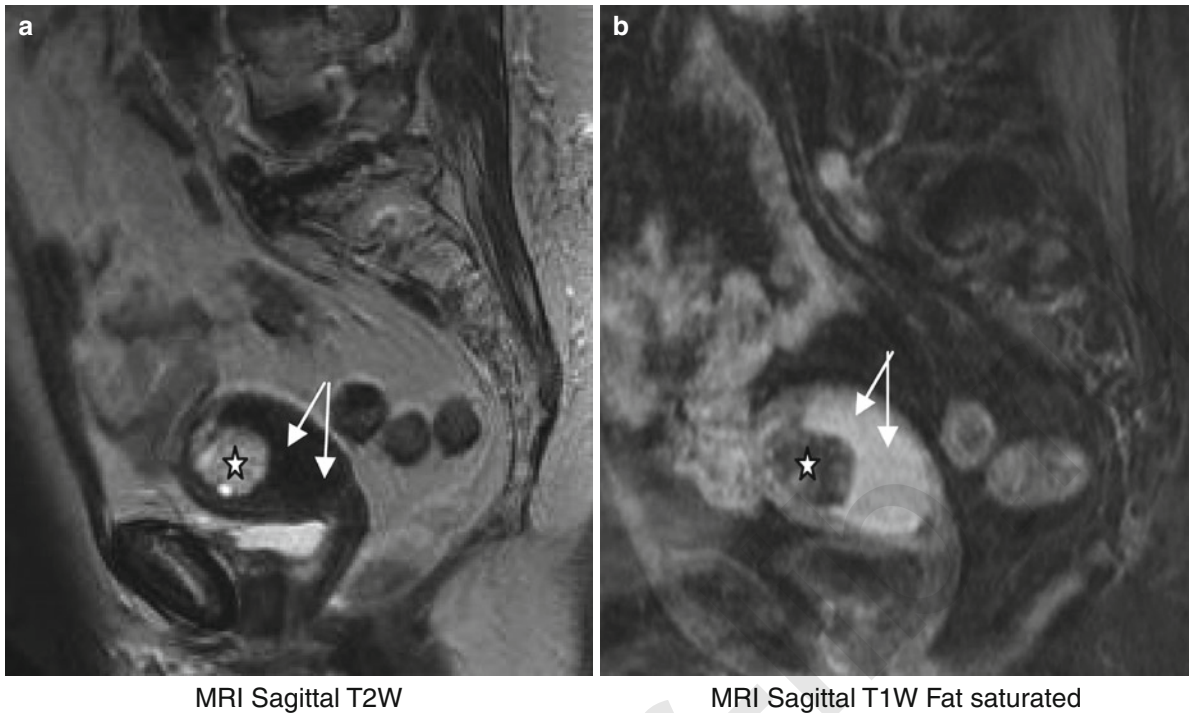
(a) MRI sagittal T2W. (b) MRI sagittal T1W fat saturated. Post-menopausal patient with vaginal bleeding and cervical stenosis. Endometrial cavity is distended with blood (*arrows*) bright on T2 weighted sequences and dark on T1 weighted sequences. A typical hyperplastic benign high signal fundal
